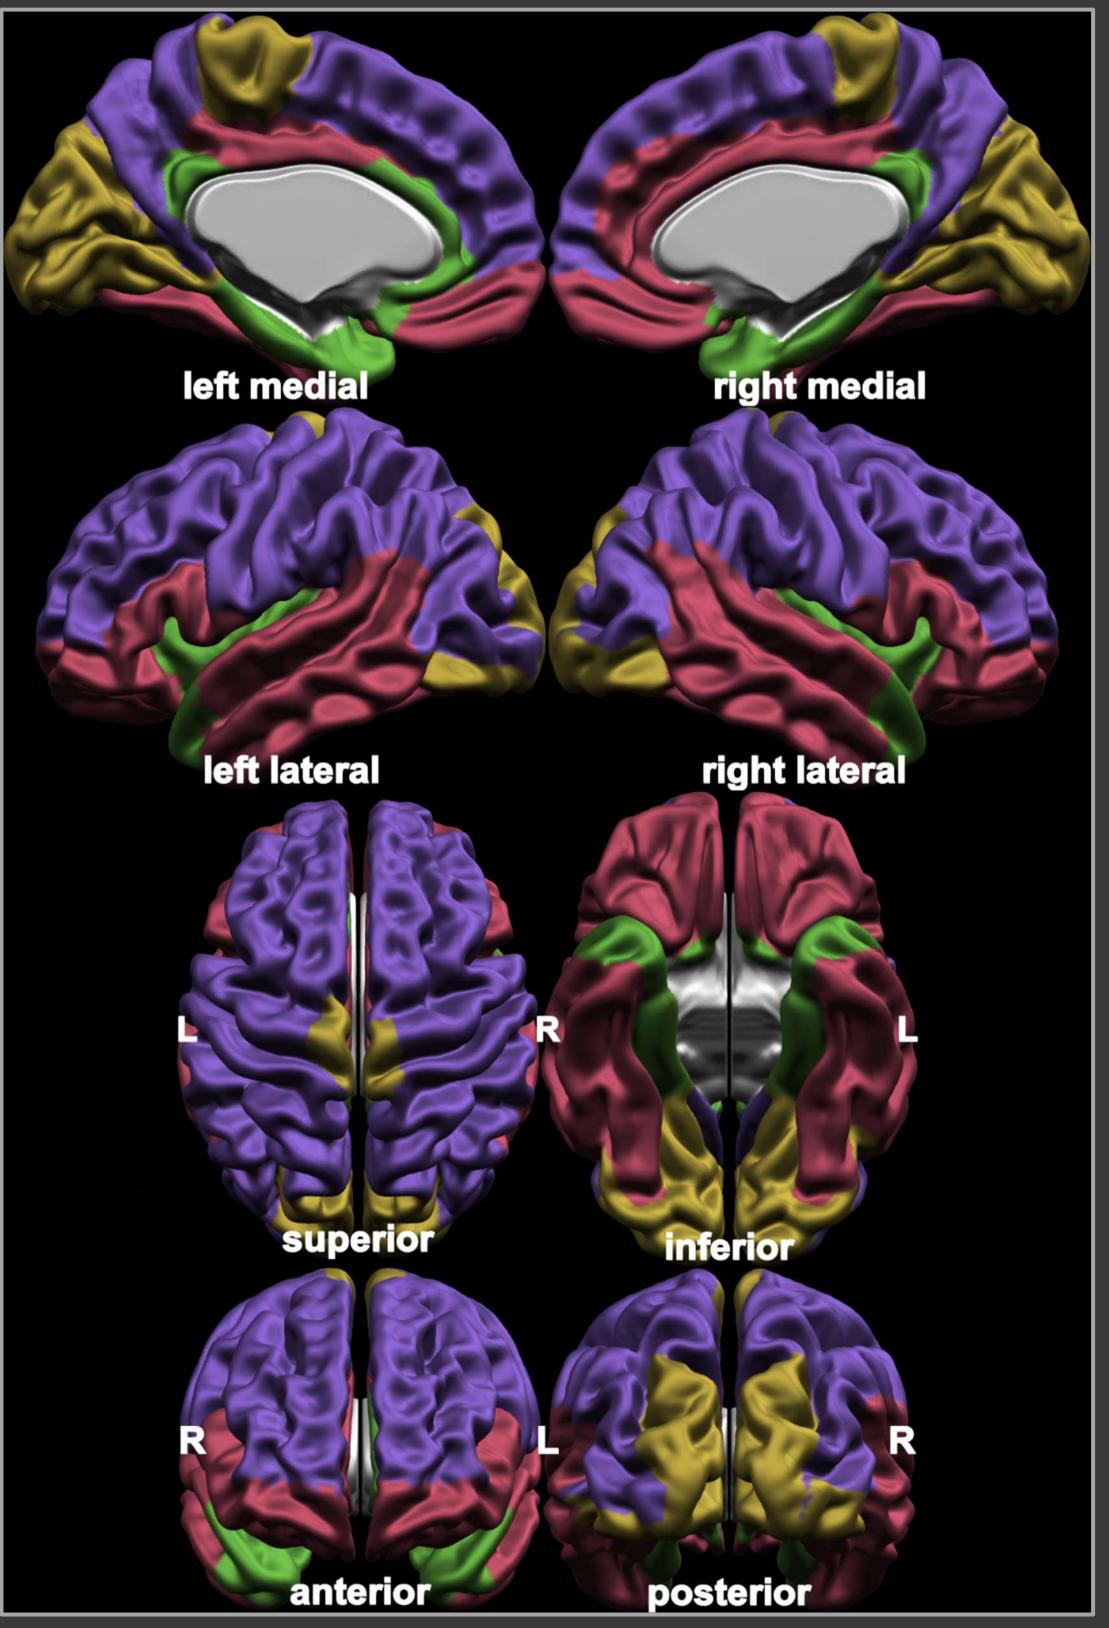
Four modules of <u>structurally</u> correlated mean CT across ROIs
